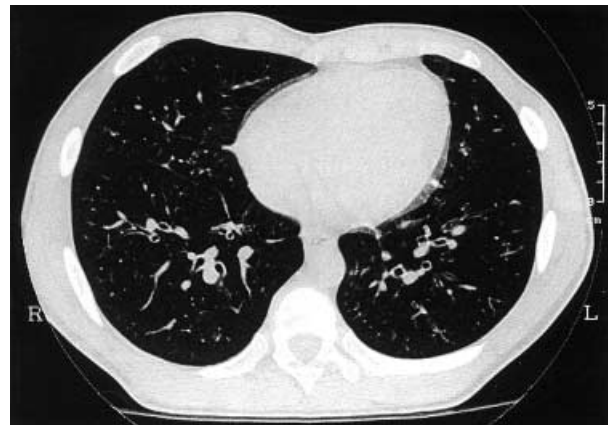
Slide of HRCT scan, showing bronchiectasis in patient 1.
